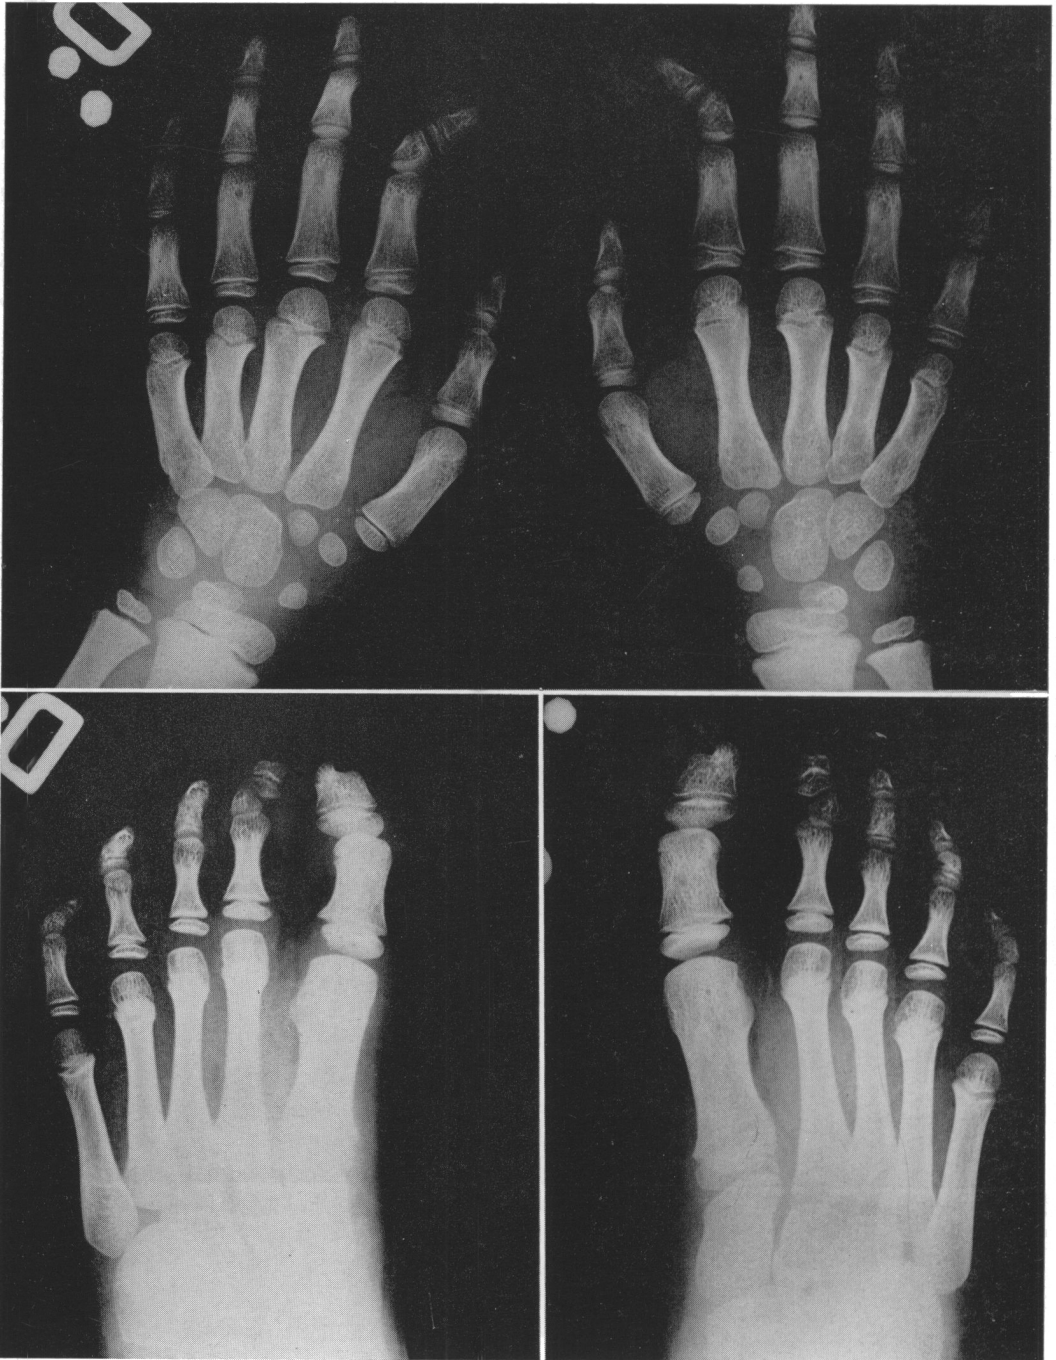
Roentgenograms of hands and feet of propositus at 7 years. The same osseous anomalies are evident.
